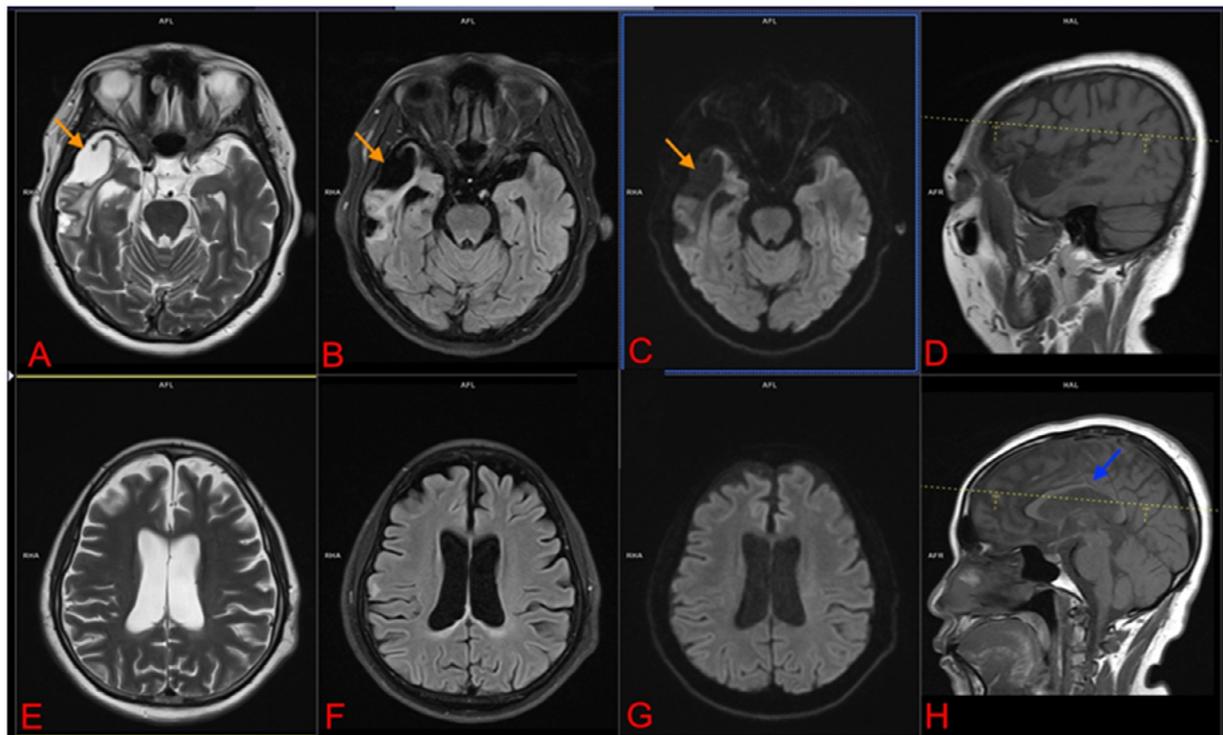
(A-D) show the old brain lesion in the right temporal lobe, hyperintensity on T2W, and hypointensity on T1W and FLAIR–DWI (orange arrow). (E-G) show normal cerebral signal intensity on MRI. (H) is the sagittal T1W image of the corpus callosum showing a reduction in its size (blue arrow).
